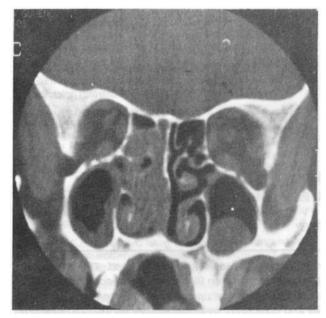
Preoperatif HRCT
